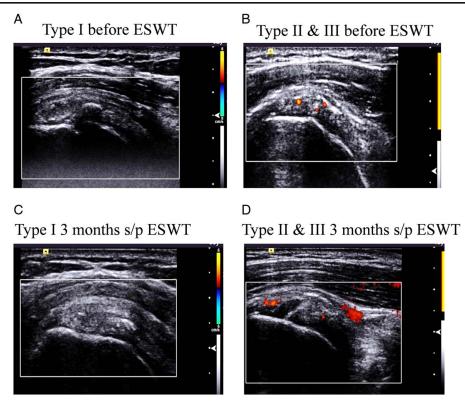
Sonographic analysis. (A) Type I calcification density before ESWT. (B) Type II and III calcification density before ESWT. (C) Type I calcification density after ESWT at 3 months. (D) Type II and III calcification density after ESWT at 3 months. Red color indicates the blood flow.
